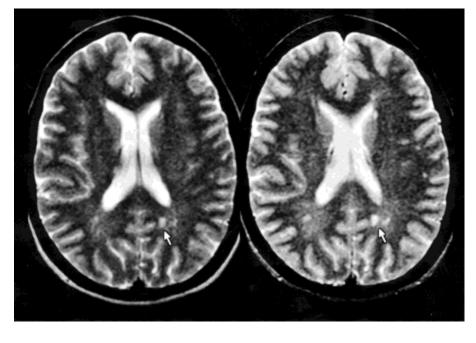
T2-weighted FSE (left) and T2-weighted CSE (right) transverse images of the brain demonstrating a higher CNR between lesions (arrows) and white matter evident on the CSE sequence.
